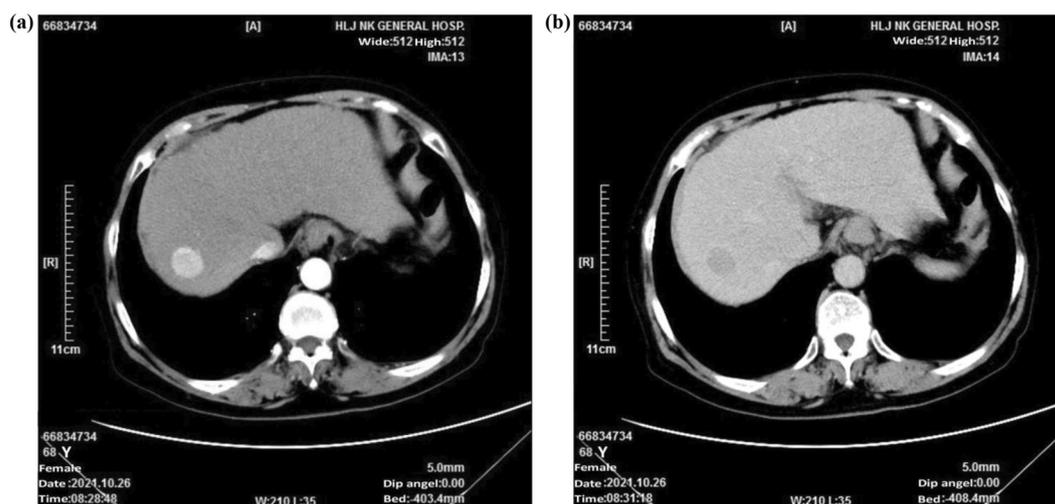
Liver enhanced computed tomography scan before treatment on October 26, 2021. (a) A size of about 21 mm × 18 mm low-density focus can be seen on the right lobe of the liver, with obvious homogeneous enhancement on arterial phase. (b) A low-density focus can be seen in the right lobe of the liver in portal phase, enhanced lower than the surrounding liver parenchyma, and boundary is still clear.
